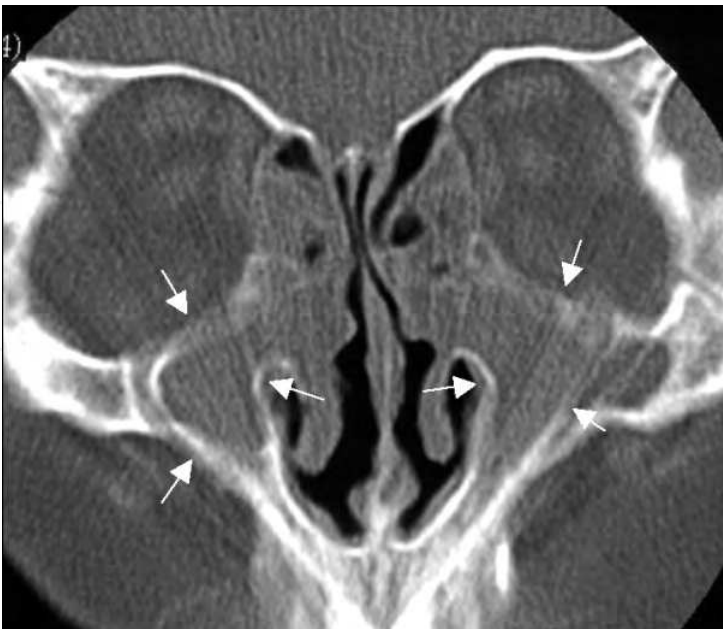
Coronal CT in a patient with silent sinusitis syndrome due to bilateral, longstanding maxillary rhinosinusitis. The maxillary sinus volumes are reduced due to the inward retraction of the sinus walls (arrows). Note also the enlarged, oval shaped orbits.
